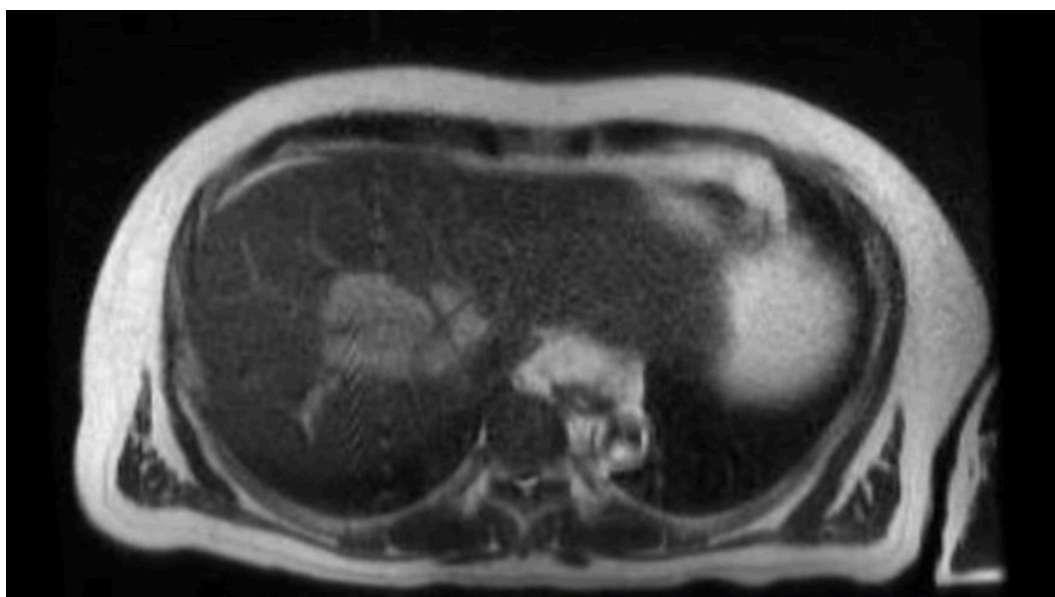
MRI of the abdomen w/wo IV contrast showing multiple peripheral enhancing diffusion restricting masses within segments 8, 1, and 6. The dominant mass measures 4.4 x 4.3cm in segment 8
